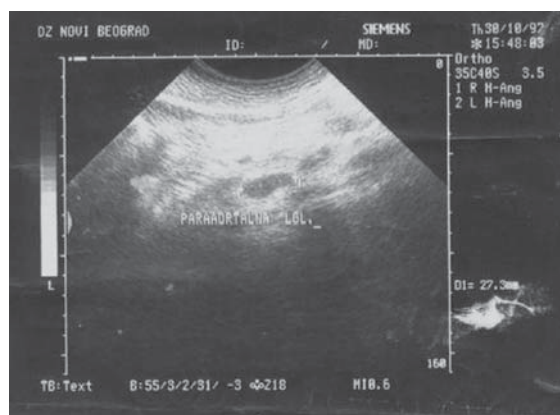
Ultrasonographic image of increased paraaortic lymph nodes.
